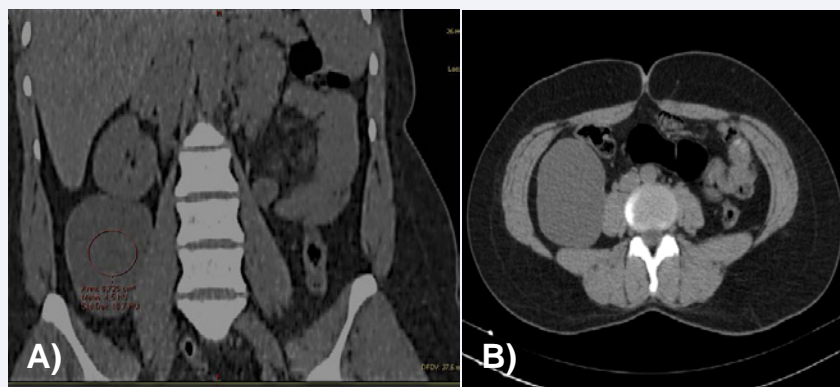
Non-contrast computed tomography of the abdomen.
